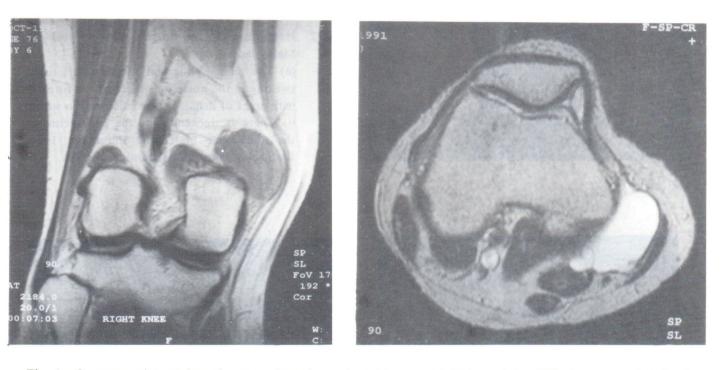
Gastrocnemius-semimembranosus bursal cyst in a 86 year old Chinese lady. MR shows a well-defined mass of low signal intensity on the (a) intermediate-weighted coronal image and homogeneous high signal intensity on the (b) T2-weighted transaxial image, suggesting it is cystic. It is located deep to the semimembranosus and sartorius muscles and lateral to the medial head of the gastrocnemius muscle and has fine septations within it.
